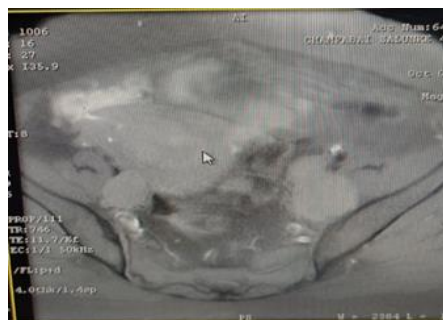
(A): MRI Pelvis shows an enhancing lesion involving endometrial cavity.
